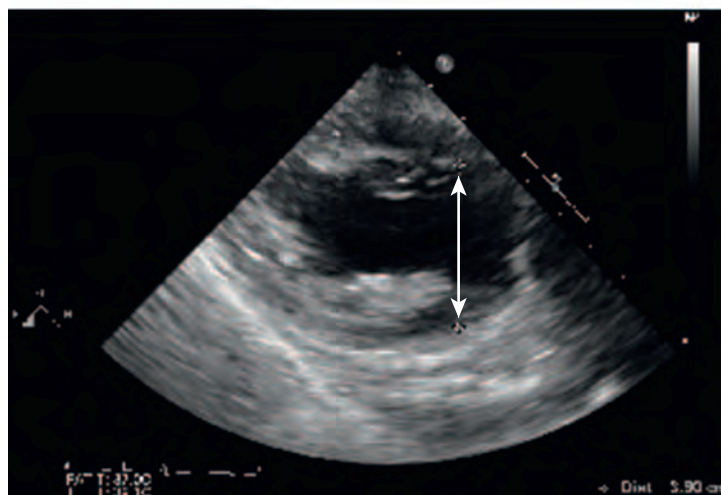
Transesophageal echocardiographic images used in the calculation of left ventricular mass. (A) Transgastric midpapillary short-axis view showing the recommended measurements of the inferolateral wall thickness diameter at end-diastole (ILWTd) and antero-septal wall thicknesses at end-diastole (ASWTd). (B) Midesophageal two-chamber view shows the measurement of the left ventricular internal diameter at end-diastole (LVIDd). (C) Transgastric 2-chamber view shows the measurement of the left ventricular internal diameter at end-diastole (LVIDd). Using the formula: Left ventricular mass (g) = $0.8 \times (1.04[(LVIDd + ILWTd + ASWTd)^3 - (LVIDd)^3]) + 0.6$. The left ventricular mass of this patient equals 84.6 grams. LA, Left atrium; LV, left ventricle; LMD, left ventricular diameter; RV, right ventricle. (Permission pending from Weiner M, Kahn RA, Evans AS. Transesophageal echocardiographic assessment of left ventricular mass. *Anesth Analg*. 2015;121:323–328.)
